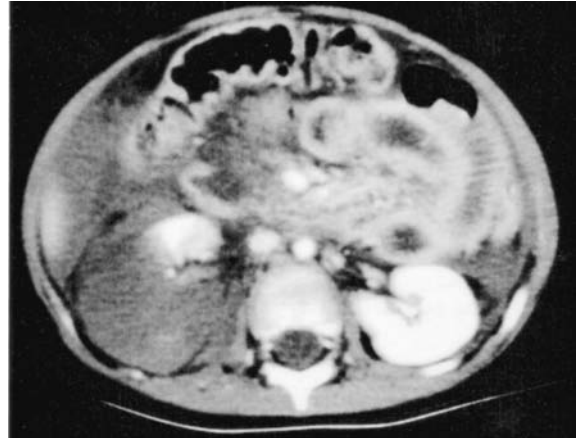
CT scan with contrast. Two images demonstrating transection of the upper pole of the right kidney in an 18-month-old child. Seatbelt injury sustained in road traffic accident. An associated duodenal rupture was managed by laparotomy but the renal injury was treated conservatively.
